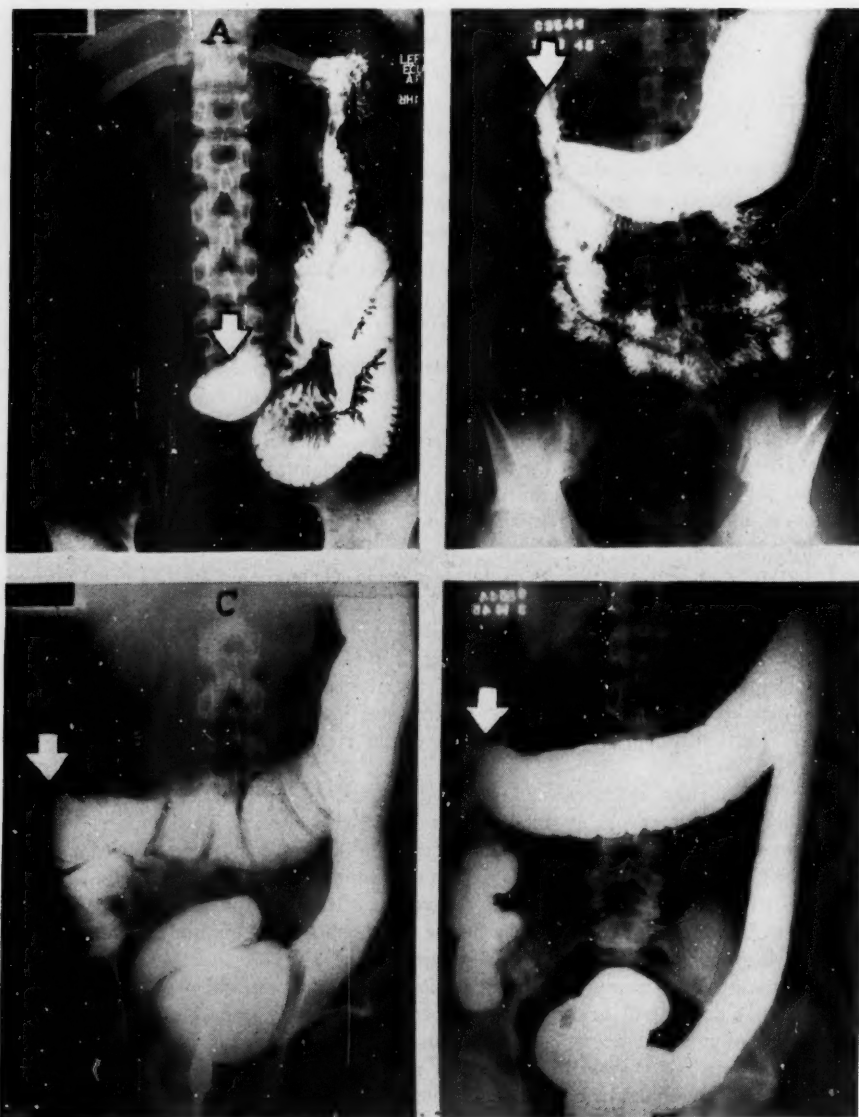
Roentgenologic studies in Case 1, in which the cyst was excised. Arrow in (A) shows displaced stomach and duodenum preoperatively, and in (B) the return to normal position postoperatively. Arrow in (C) shows displaced hepatic flexure of colon preoperatively, and in (D) the return to normal position postoperatively.
